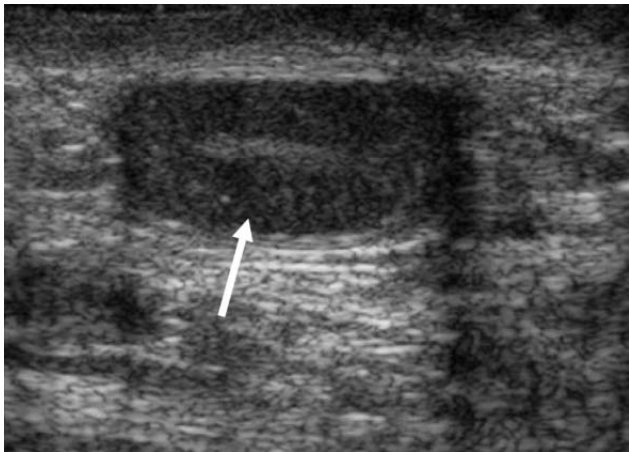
Ultrasonic imaging of a one-year old boy with an undescended testis. This image shows normal size, oval-shaped hypoechoic testis with thin central hyperechoic line, representing a mediastinal testis (indicated by arrow) located in the inguinal canal.
